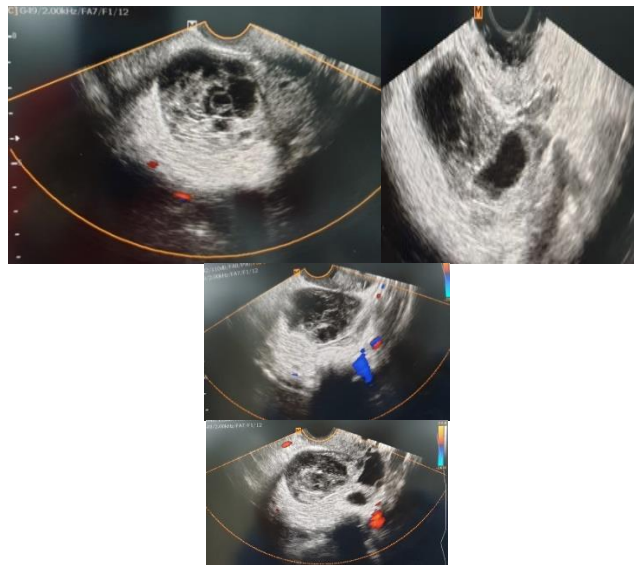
Pelvic and vaginal ultrasound images showing peripheral large heavy cysts (the string of pearls sign). The cysts are unilateral in ovarian torsion with abnormal morphology of the ovary (congested ovarian stroma). The “whirlpool” sign is visible as a clockwise or counter clockwise wrapping of the hypoechoic vessels around the central axis >
